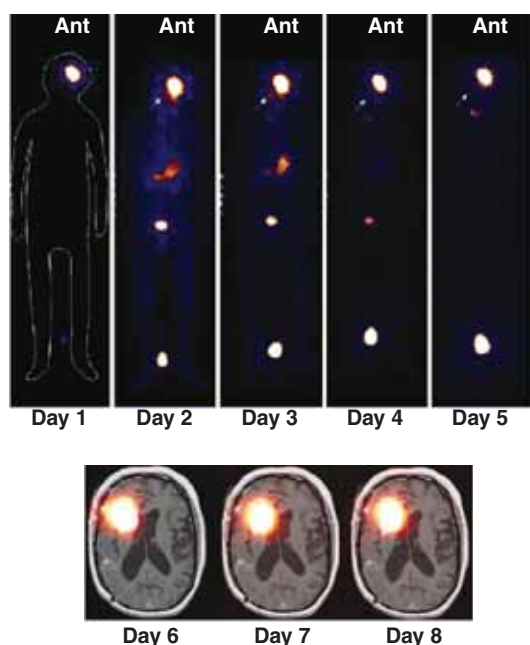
Total body planar and brain SPECT imaging of ^{131}I -TM-601 following a single intracavitary 10 mCi dose. The bright region noted between the legs in the total body planar images is a 1 mCi standard. Retention of the peptide at the tumor cavity site (left side of head) is evident on days 1 – 5, with minimal uptake anywhere else in the body. The loss of a signal in the images roughly approximated the physical decay constant of ^{131}I , indicating long-term retention and minimal biological elimination at the tumor site, with rapid elimination elsewhere. Axial SPECT scans co-registered to MRI indicate long-term retention at the tumor cavity site, with a volume of distribution that approximates well to the tumor volume.
